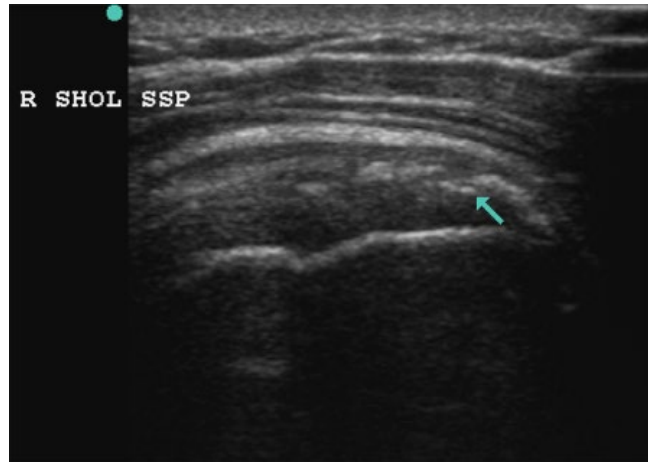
Ultrasound of the shoulder. Patient position #4 during the ultrasound examination.
